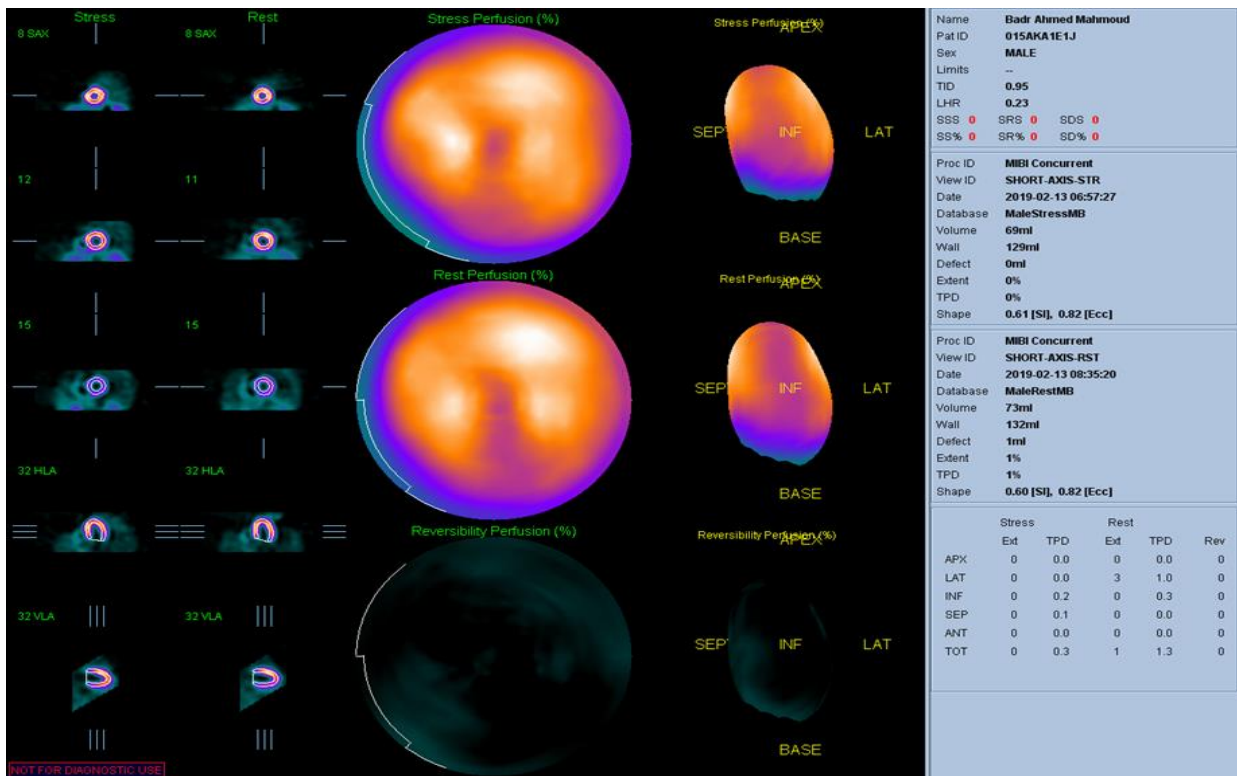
Gated SPECT study of one of our patients
